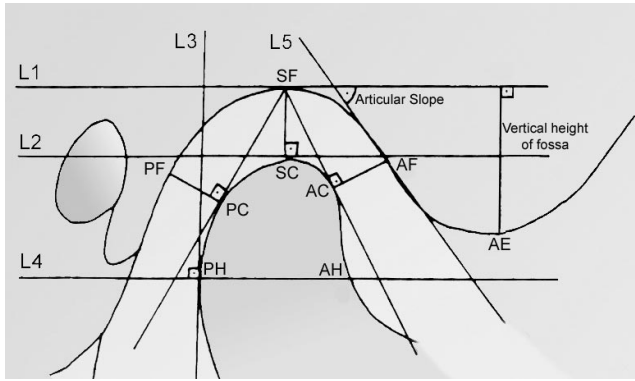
Measurements from transcranial temporomandibular joint radiographs: AJS, anterior joint space between AC and AF (mm); PJS, posterior joint space between PC-PF (mm); SJS, superior joint space between SC-SF (mm); condylar width, distance between AH and PH (mm); vertical height of articular fossa as the measurement of a perpendicular line extending from AE to line 1 (mm); angle of articular slope ($^{\circ}$); percentage of posterior to anterior joint space (%).
